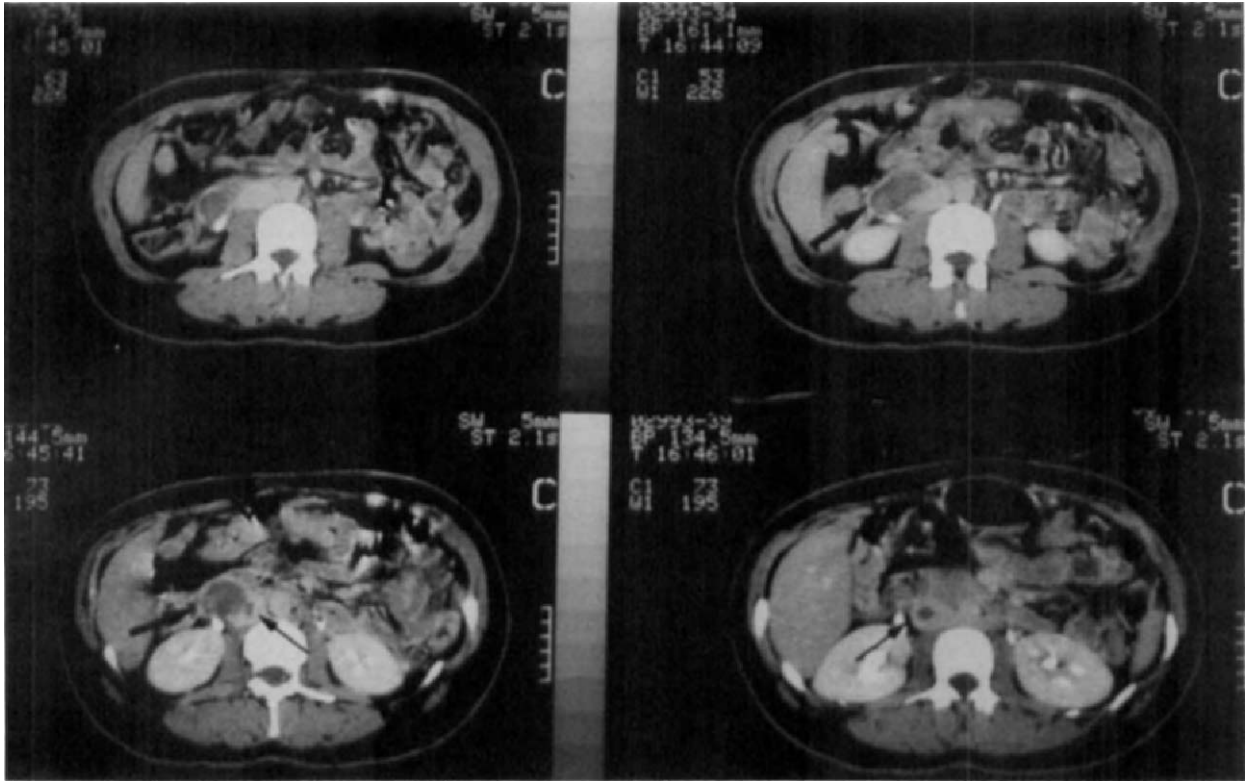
Preoperative abdominal CT scans. The small arrow shows the thrombus in the IVC; the large arrow shows the voluminous thrombosed right ovarian vein.
